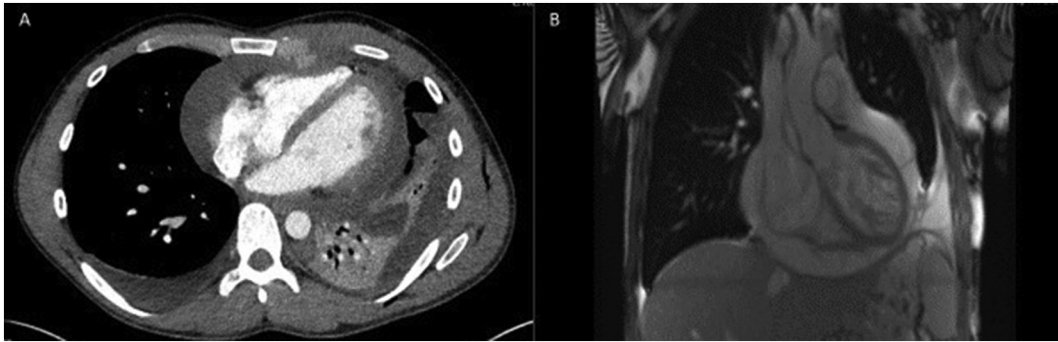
Panel A - Repeat CT imaging which confirmed the presence of an enlarging pericardial effusion and bilateral pleural effusions. Panel B - MRI scan demonstrating the pericardial effusion.
